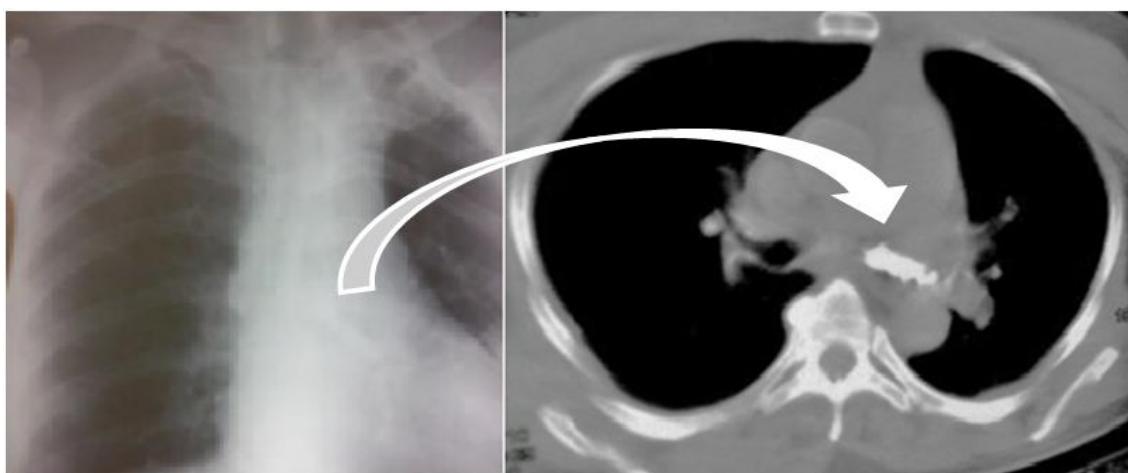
Multiple radiopaque foreign bodies are seen in left mainstem bronchus (Portable chest x-ray and CTT)
